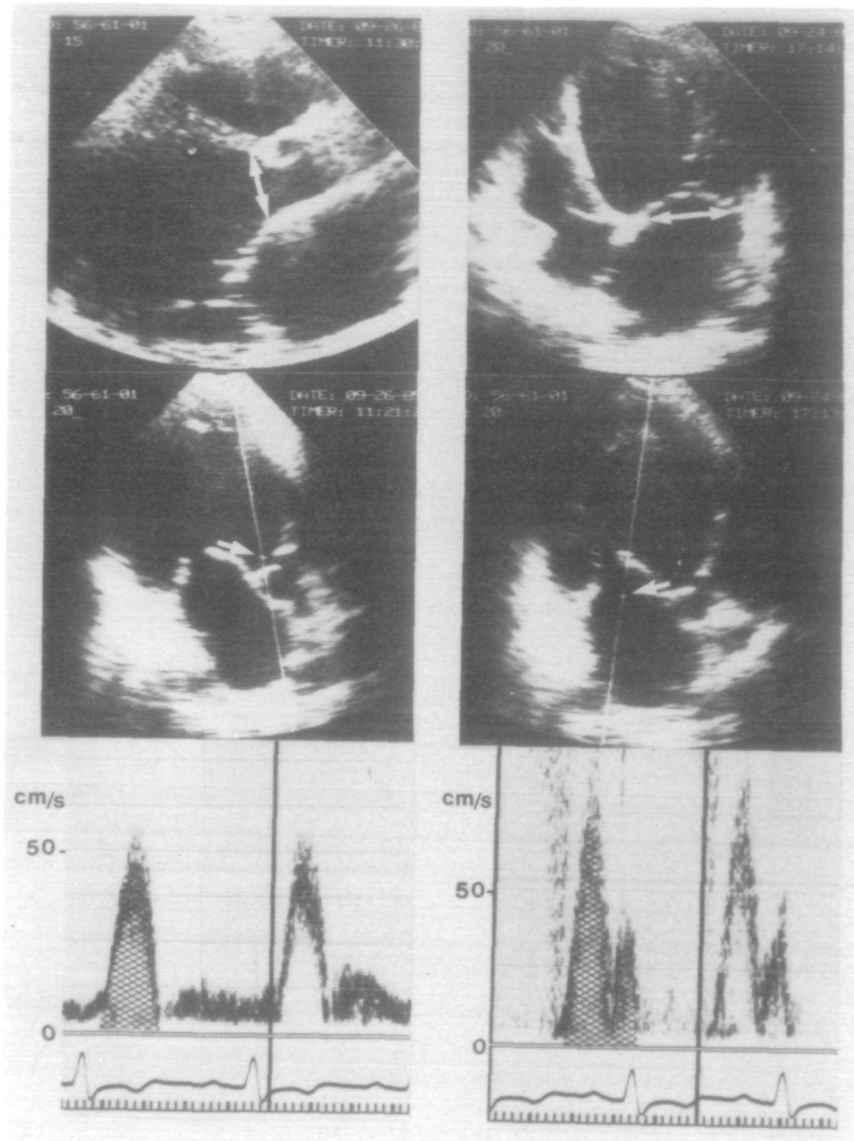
Measurement of volume flows in mitral regurgitation. Left panels—determination of forward flow. Left ventricular outflow tract diameter (double-headed arrow, top) is measured from an apical view, and flow velocity is recorded just below the aortic valve (arrowhead, center) using pulsed Doppler. The systolic velocity integral (shaded area, bottom) is planimeted. Right panels—determination of total flow. Mitral annular diameter (double-headed arrow, top) is measured from an apical view, and diastolic transmitral flow recorded from the region of the annulus (arrowhead, center) using pulsed Doppler. The diastolic velocity integral (shaded area, bottom) is planimeted. In this example from a patient with severe MR, the Doppler regurgitant fraction was 70%.
